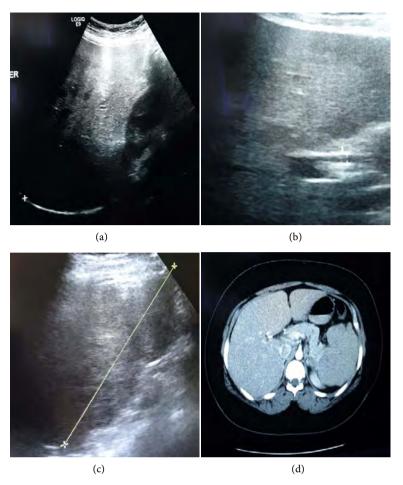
Abdominal ultrasound & CT. (a) Mildly enlarged bright liver measuring about 20 cm in the mid-clavicular craniocaudal dimension; (b) Removed gall bladder with normal diameter of CBD measuring about 5 mm; (c) Enlarged spleen measuring about 14 cm in craniocaudal dimension with irregular outline due to old infarcts; (d) Axial CT image showing hepatosplenomegaly surgical clips of cholecystectomy irregular outline of the.
